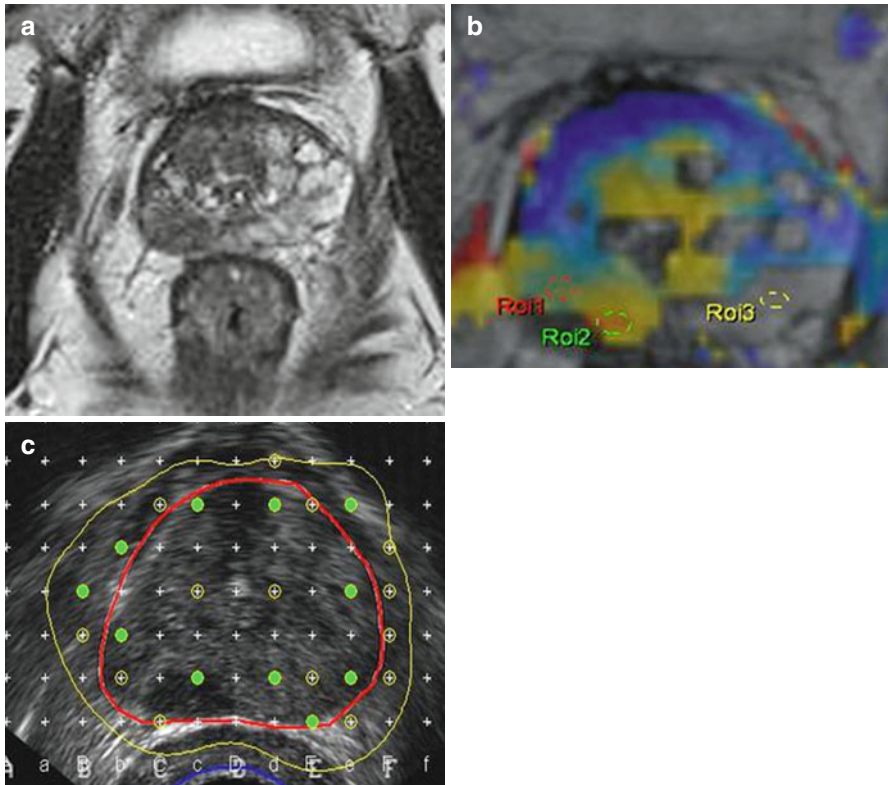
(a) Tumour in right peripheral gland on T2-MRI. (b) Corresponding tumour on DCE-MRI. (c) Intraoperative TRUS during brachytherapy
